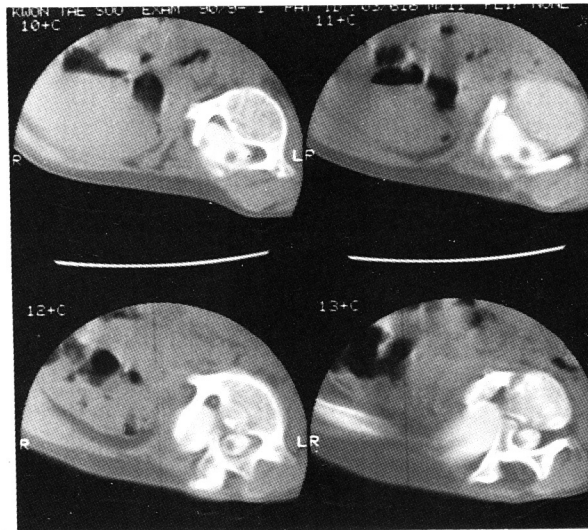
Case 3. CT scans with the intrathecal injection of metrizamide demonstrate a bony septum splitting the lumbar spinal cord.
